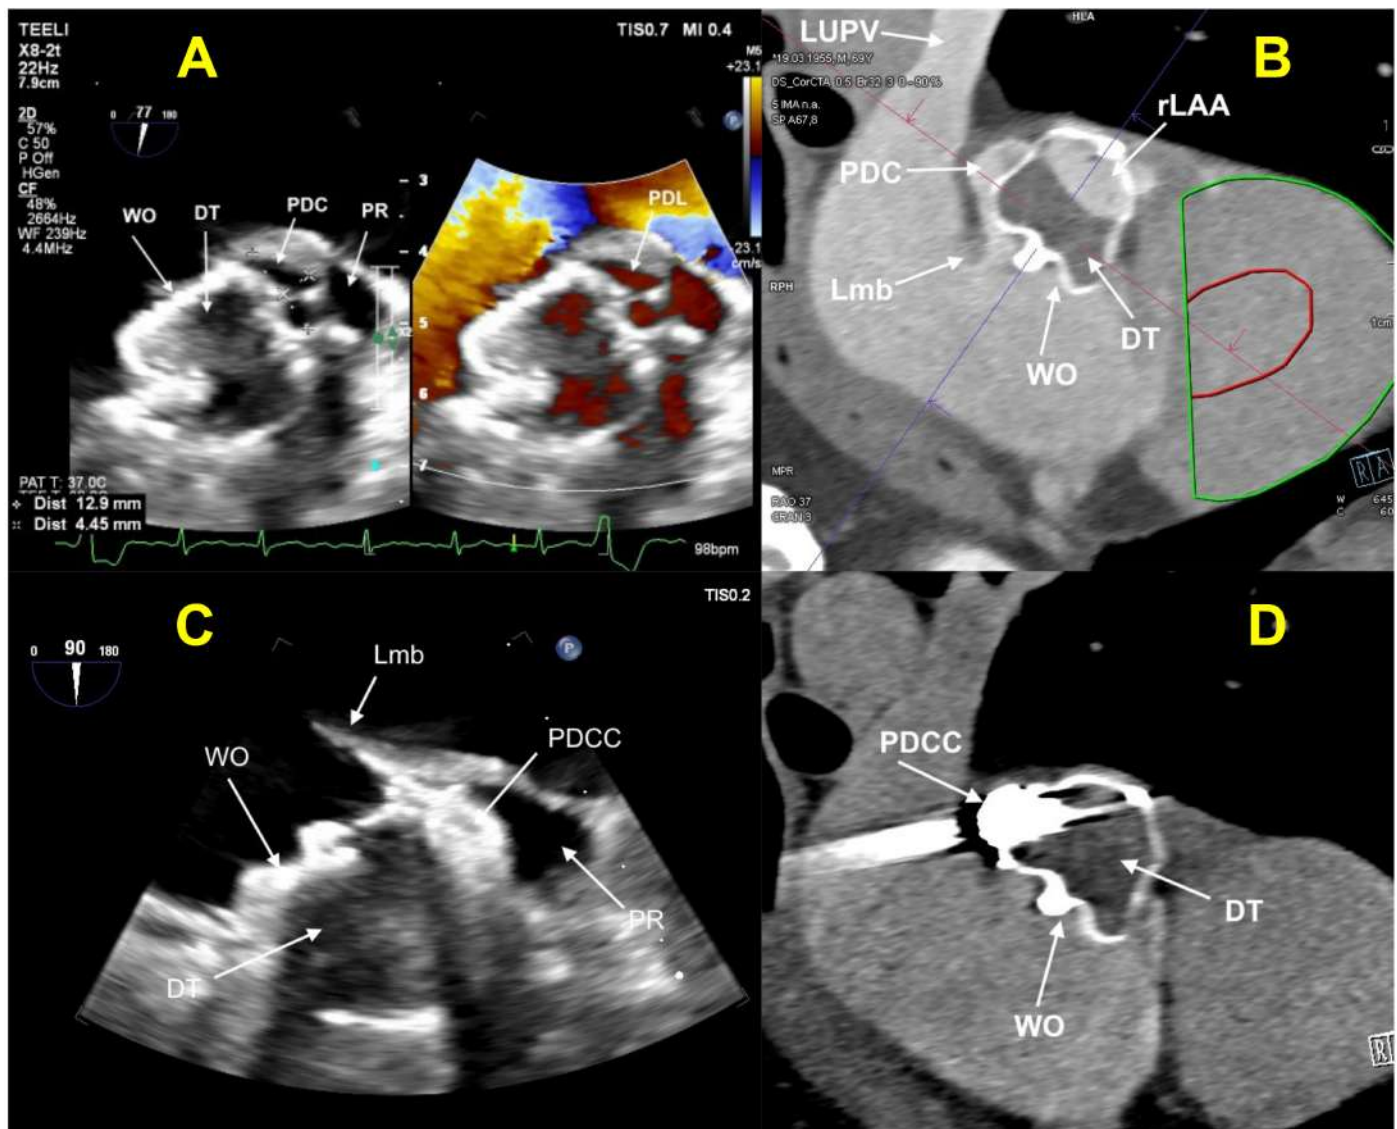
Posterosuperior peridevice leak and device-related thrombus: multimodality. Imaging before and after coil embolization. (A) Two-dimensional TEE with color Doppler demonstrates the WO with an echogenic mass representing DT located under the skirt of the occluder. A posterosuperior PDC (12.9 × 4.45 mm) is visualized adjacent to the occluder. Color Doppler reveals the PDL with flow communication between the rLAA and left atrium. The PR is identified as a distinct structure separate from the pathologic cavity. (B) Contrast-enhanced cardiac CT with multiplanar reconstruction demonstrates the complex anatomy of the PDC and its relationship to the LUPV, Lmb, and residual LAA. Device-related thrombus appears as a hypoattenuating mass within the WO. (C) Follow-up TEE 3 months after coil embolization demonstrates the PDCC with densely echogenic coil material. The Lmb and PR remain visualized as distinct anatomic landmarks. Complete PDL closure is achieved, with planned thrombolysis evident. The DT now fills the entire residual LAA cavity—a desirable outcome confirming flow elimination. (D) Follow-up contrast-enhanced CT confirms complete occlusion with the PDCC showing no contrast opacification despite left atrial enhancement, indicating elimination of the peridevice leak. The WO and persistent DT are visualized. CT, computed tomography; DT, device thrombus; LAA, left atrial appendage; Lmb, limbus; LUPV, left upper pulmonary vein; PDC, peridevice cavity; PDCC, peridevice cavity closure (coil-filled); PDL, peridevice leak; PR, pericardial recess; rLAA, residual left atrial appendage; TEE, transesophageal echocardiography; WO, Watchman occluder.
